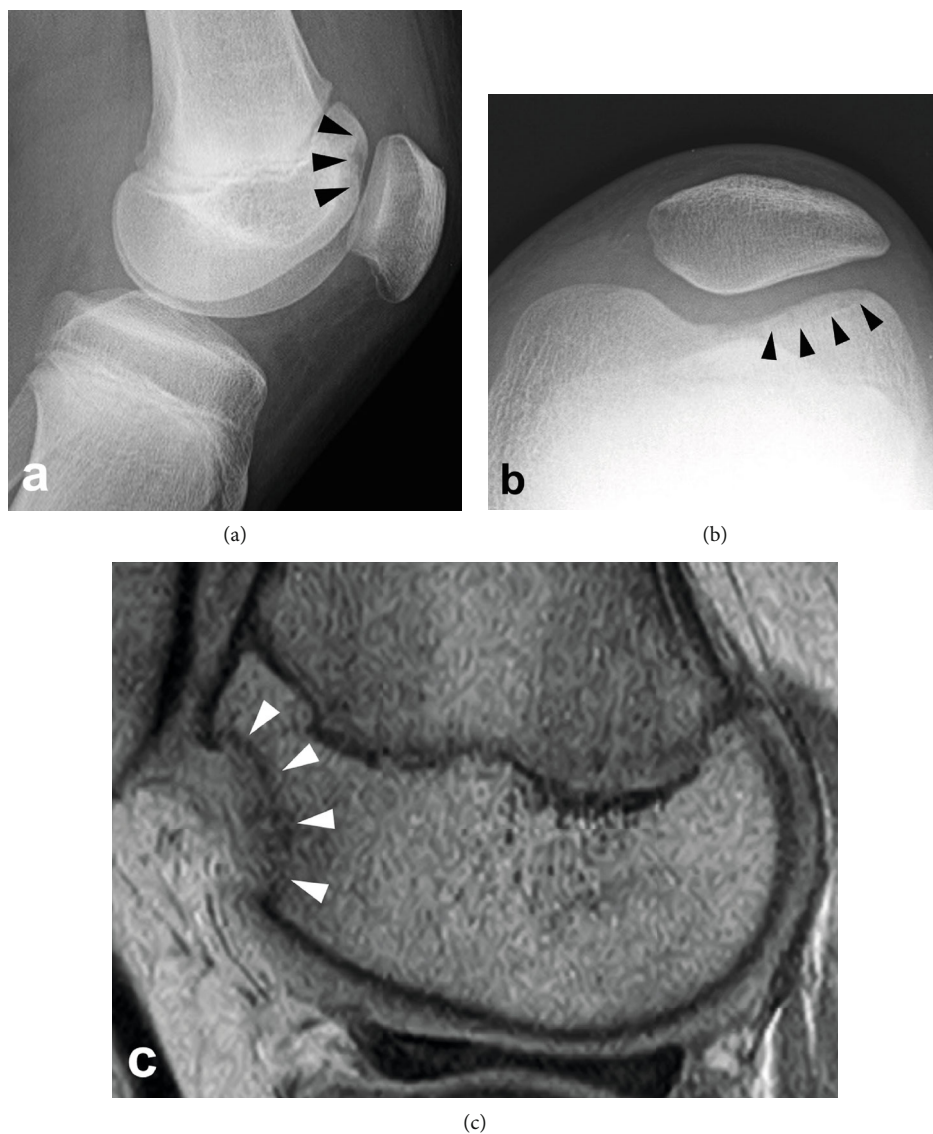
(a) Lateral view and (b) skyline view radiograph of the left knee showing Brückl's stage V OCD lesion in the lateral facet of the femoral trochlea. (c) Proton density-weighted MRI sagittal image of the left knee indicating Nelson's stage III lesion in the lateral facet of the femoral trochlea.
